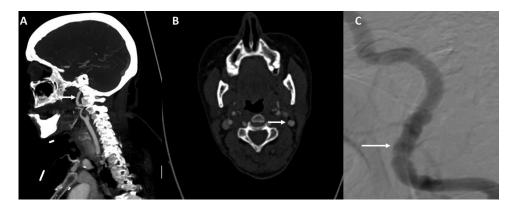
Vascular imaging in a young female patient presenting with acute aphasia and right hemiparesis. Sagittal view (A) on CT angiogram demonstrates mild irregularity with beading in the distal cervical segment of the left internal carotid artery (white arrow) and a dissection in the proximal internal carotid artery soon after the bifurcation seen on axial views (B), white arrow)). Magnified lateral view (C) on digital subtraction angiogram of right internal carotid artery confirms mild "beading" in the distal cervical segment of the carotid.
